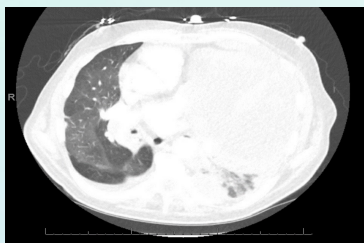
CT chest demonstrates extensive pleural based masses in left lung with loculated pleural effusion producing near-complete atelectasis of the left lung. Also noted is shift of heart and mediastinal structures to right.
